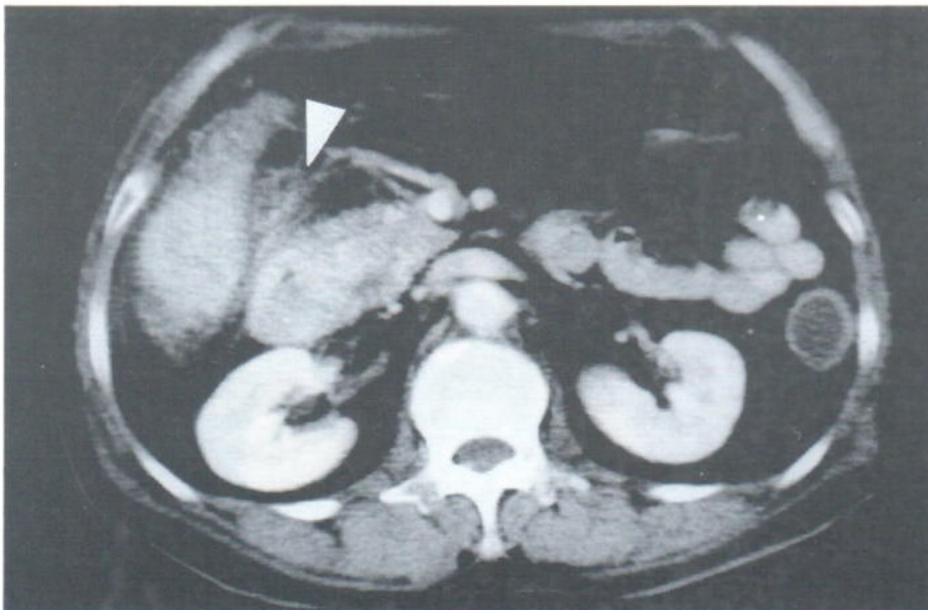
Papillary adenocarcinoma : CT scan of upper abdomen post contrast enhancement of female 71 years old showed inhomogeneous enhancing irregular polypoid mass (arrow) in the gall bladder lumen.
